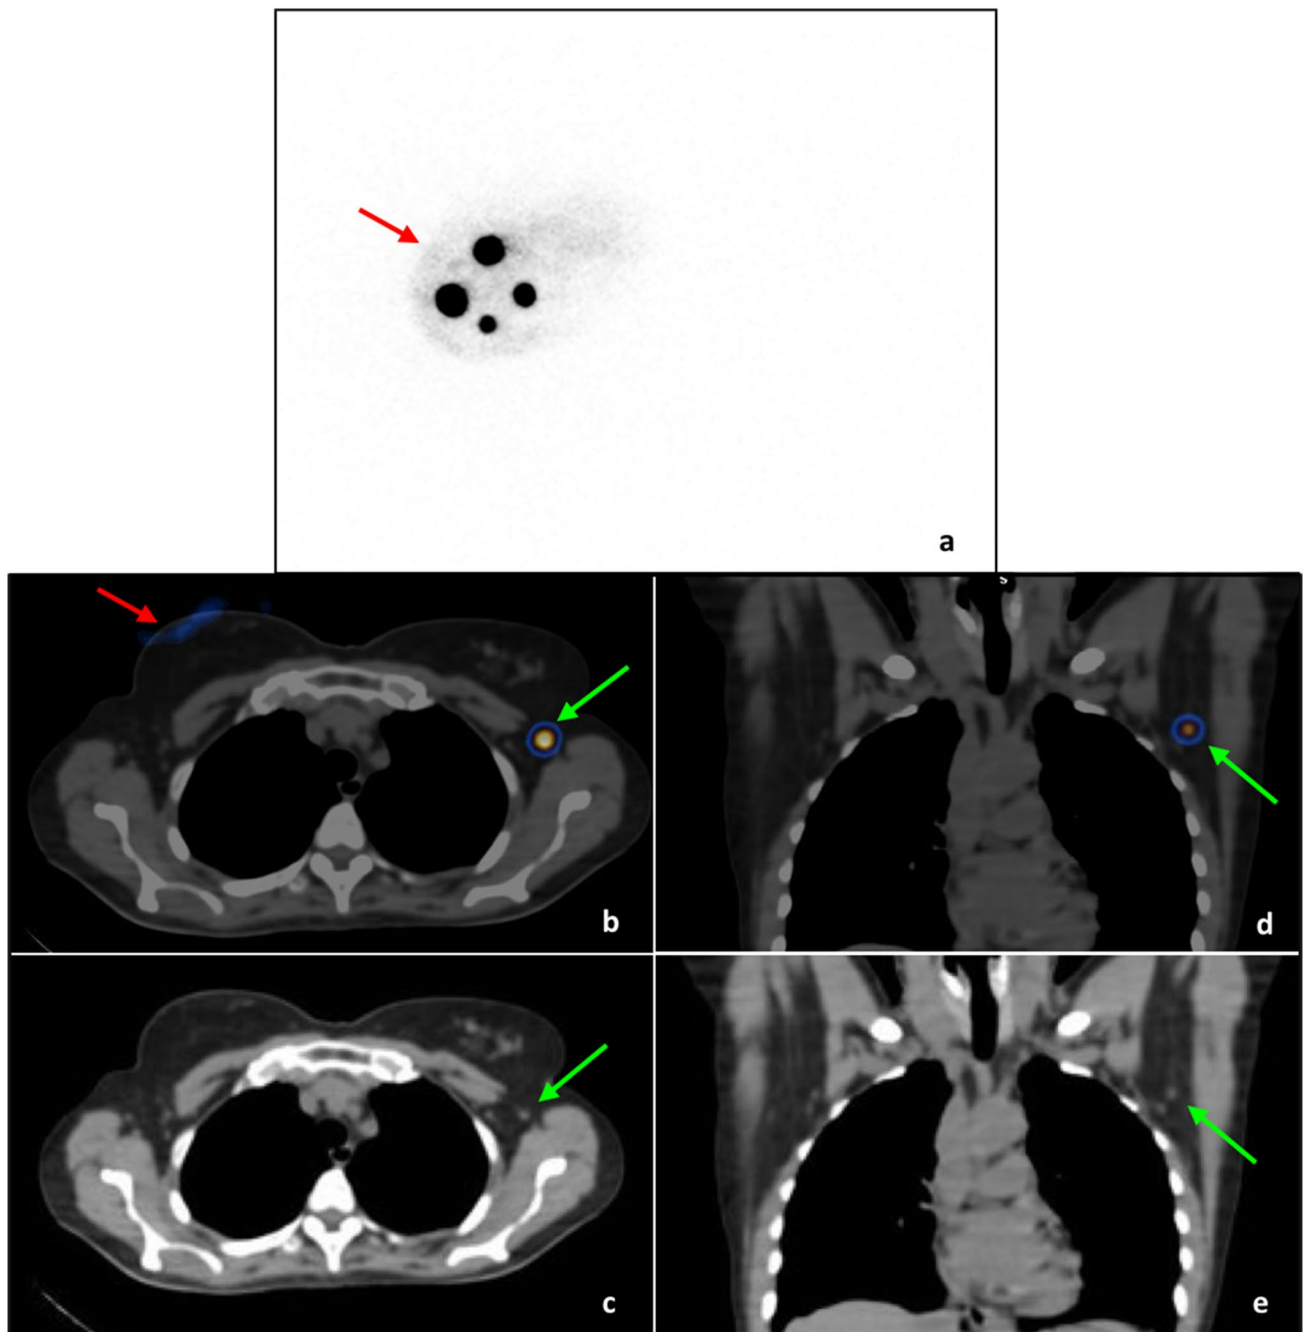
Lymphoscintigraphy of a 57-year-old woman performed for relapsed right breast cancer, already treated with neoadjuvant chemotherapy and surgery (clinical case #1). a Planar static image, anterior projection, of the right breast. b–e SPET/CT images (Optima NM/CT 640, GE, Milwaukee, USA—128×128 matrix, angle rotation of 180 degrees for each detector, 20 s per view): b axial fused SPET/
